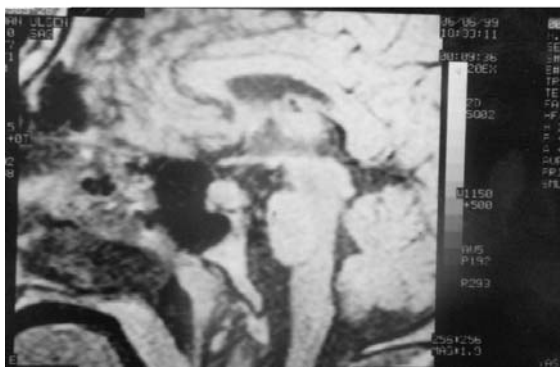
Magnetic resonance imaging of pituitary microadenoma
